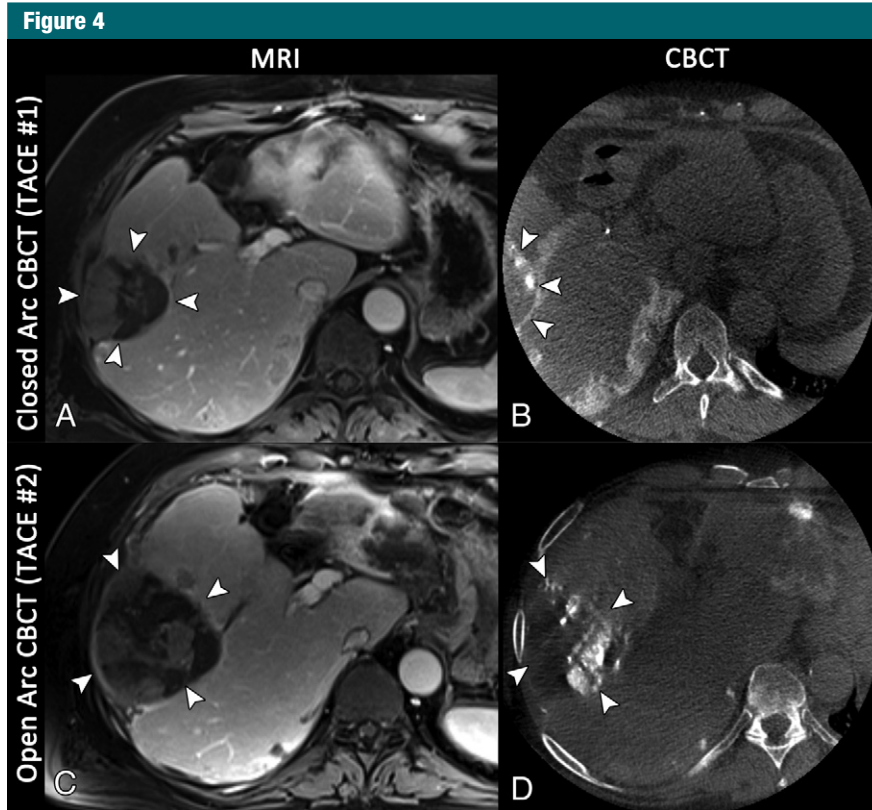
Axial images in a 72-year-old man with multifocal hepatocellular carcinoma, with the index lesion in segment 6. *A*, Baseline T1-weighted MR image acquired in the portal venous phase shows the index lesion in segment 6 (arrowheads). *B*, Reconstruction of the closed arc cone-beam CT (CBCT) data acquired during the first conventional TACE procedure depicts the tumor only to a limited extent (arrowheads), owing to suboptimal centering of the FOV. *C*, Follow-up MR image acquired 4 months later demonstrates extensive growth of the tumor (arrowheads); the patient was referred for another cycle of conventional TACE. *D*, Even though the tumor has grown, the axial reconstruction of the open arc cone-beam CT data from the intraprocedural imaging depicts the complete tumor (arrowheads).
